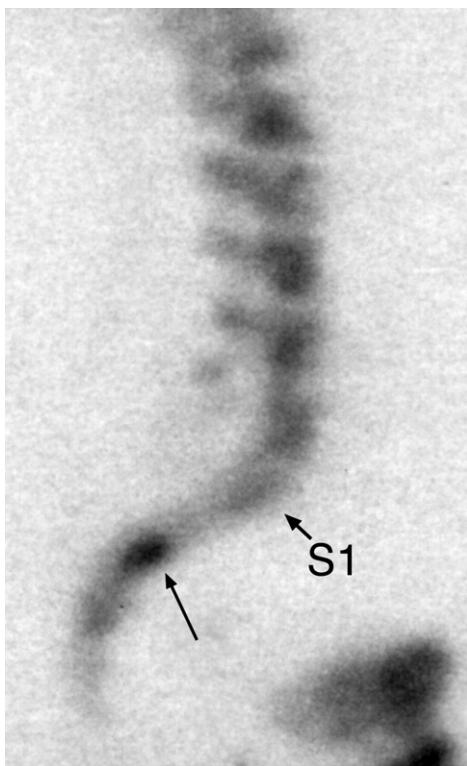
Lateral lumbosacral spine Dynamic Localized Bone Scan with SPECT image. Note the mildly increased uptake extending across the mid-sacrum at the level of the inferior sacroiliac joints (arrow). S1 = first sacral segment.
